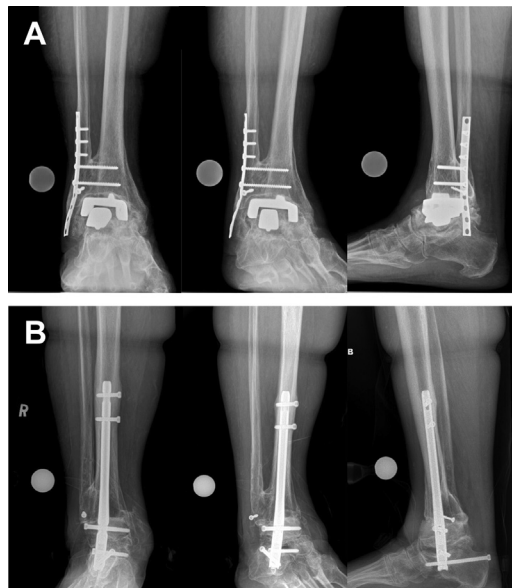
(A) Weight-bearing radiographs 12 years following a right TAA in a patient with increasing right ankle pain demonstrating periprosthetic cyst formation involving the tibia and talus and with talar component subsidence. (B) Postoperative radiographs following conversion to a TTC arthrodesis with use of a femoral head allograft.
